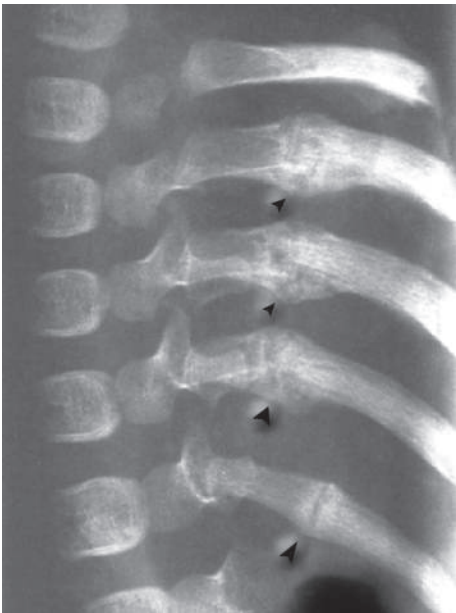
High detail oblique view of the ribs of a 6-month-old infant shows multiple healing posteromedial rib fractures (arrowheads). The level of detail in the image is far greater than what would be present on a standard chest radiograph. (From Dwek JR. *The radiographic approach to child abuse*. Clin Orthop Relat Res. 2011;469:776–789, Fig. 4.)
